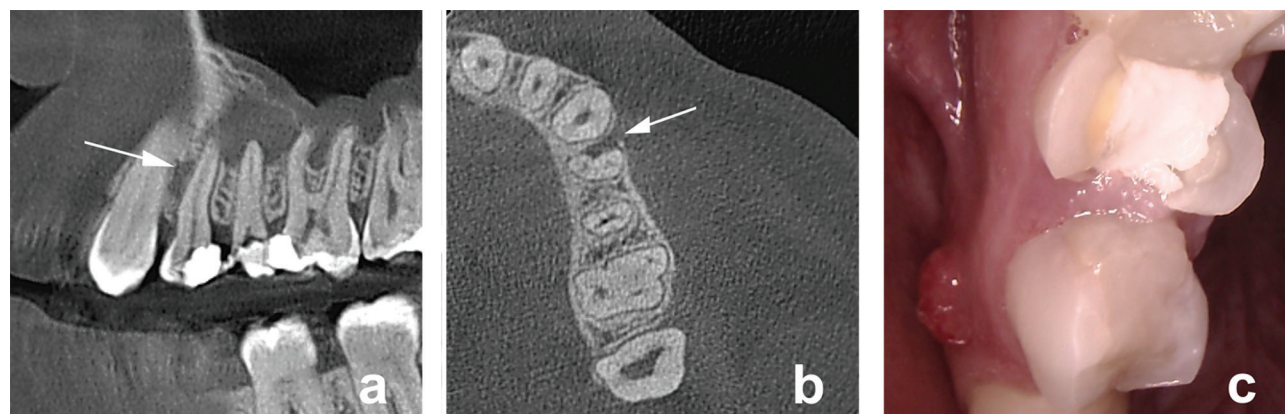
CBCT evaluation of teeth 24 and 25 before treatment. (a) Sagittal section; (b) Axial section; white arrow indicates fistula tract connected with marginal periodontitis; (c) Intraoral view of teeth 24 and 25 before treatment.
